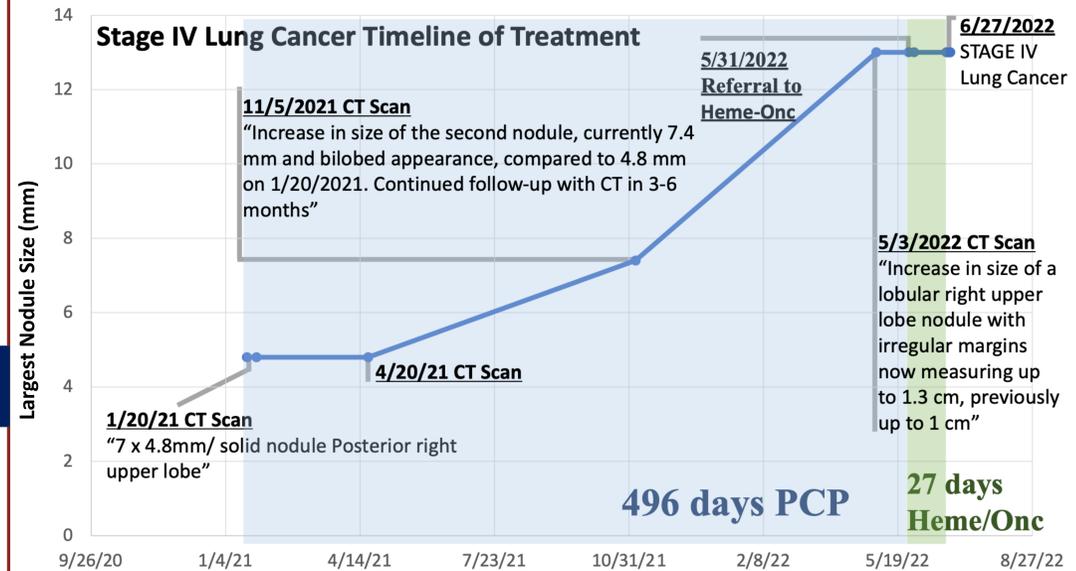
Example of Stage IV Lung Cancer Diagnosis Timeline of Treatment. Y-axis measures the largest lung nodule size (mm) for each indicated date (X-axis). Patient received a CT Chest w/o IV Contrast, which revealed 7x4.8mm solid nodule at the posterior right upper lobe. Patient received a total of 496 days of observation with primary care (PCP) before being referred to Hematology/Oncology. (Heme-Onc) Patient received 27 days of observation between the date of referral to initial consult date with Hematology/Onc.
